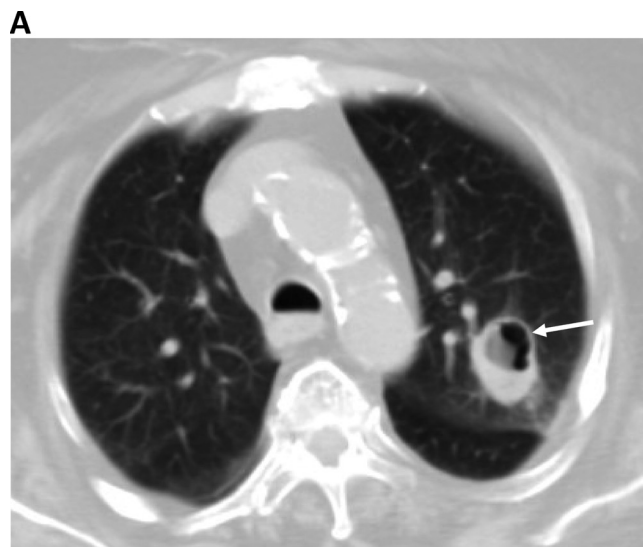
(A) Initial chest computed tomography (CT) imaging showing cavitating lesion in anterior segment of lung left upper lobe (arrow). (B) Follow-up chest CT image showing regression of cavitating lesion after 1 week of voriconazole therapy.
